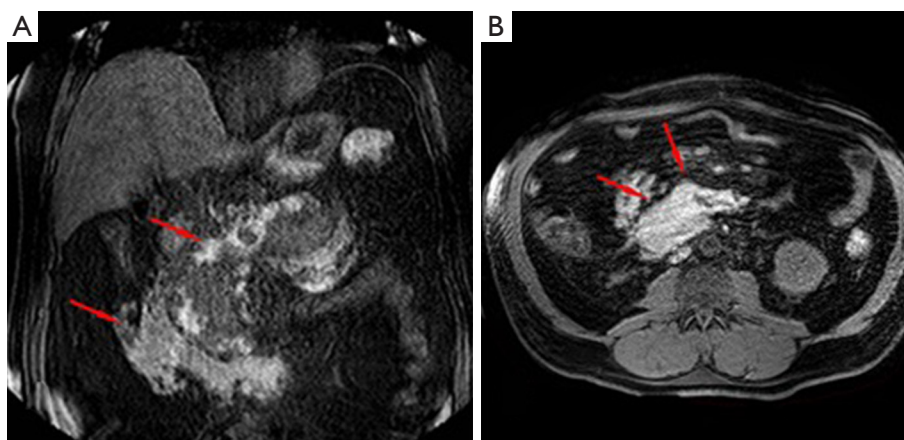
ANC in unenhanced T1-w fat-sat coronal (A) and axial (B) images with evidence of haemorrhagic collection (red arrows). ANC, acute necrotic collections; T1-w, T1-weighted.
